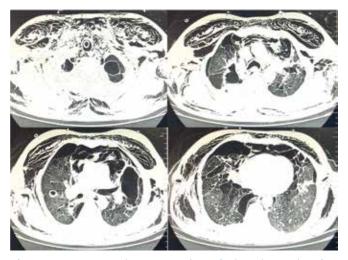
Computed tomography of the chest showing extensive subcutaneous emphysema with bilateral pneumothoraces with pneumomediastinum; lungs show evidence of bullous emphysema.
